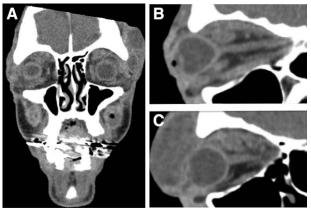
CT maxillofacial demonstrating bilateral orbital cellulitis with midface abscesses of upper alveolar origin (A), right globe tenting (B), and left pre- and post-septal abscesses (C).
